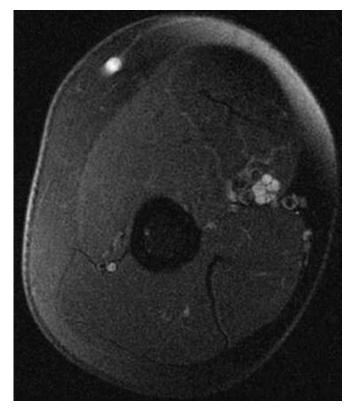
Failed carpal tunnel syndrome. A 55-year-old man presented with progressive numbress in the dominant left thumb, index, and middle fingers over 5 years. He did not benefit at all from left endoscopic carpal tunnel release performed 3 years earlier by his surgeon. He did not relate any paresethesisas or weakness, nocturnal, or positional symptoms. Motor examination was entirely normal. Two-point discrimination was greater than 15 mm in the radial 3 ¹/₂ digits versus 4 mm elsewhere. He had no percussion tenderness at the wrist. EMG performed at his outside facility showed only a non-localizable median neuropathy. On more careful testing, he had decreased palmar sensation, suggesting a more proximal lesion. Percussion tenderness over the course of the median nerve was positive at the level of the antecubital fossa and in the distal arm. Although no bony spur was felt on examination, the possibility of a supracondylar spur and ligament of Struthers compression was suspected, but elbow x-rays did not reveal any bony abnormalities. T2-weighted fast spin echo image with fat saturation shows enlarged hyperintense fascicles within the median nerve extending for over 10 cm in the distal arm. Fascicular biopsy proved it to be a perineurioma. The neurological examination and the MRI appearance has been stable for several years.
